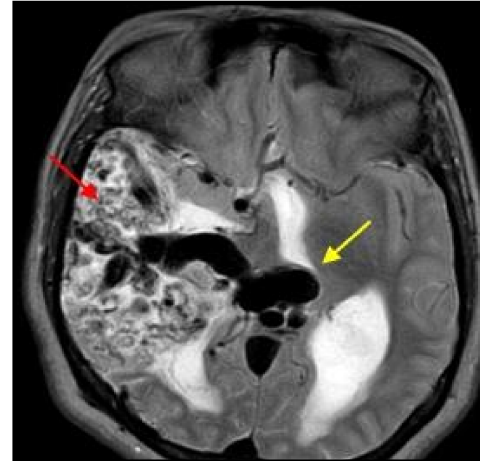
Pial AVM seen on 1.5-T T2-weighted MR axial image of the brain as a conglomerate of tortuous flow voids representing AVM in right temporal lobe [Red arrow] with feeders from right sided MCA, PCA and drainage into Vein of Galen and straight sinus. Mechanical obstruction of the third ventricle is noted at level of cerebral aqueduct by dilated and tortuous Vein of Galen. [Yellow arrow]
